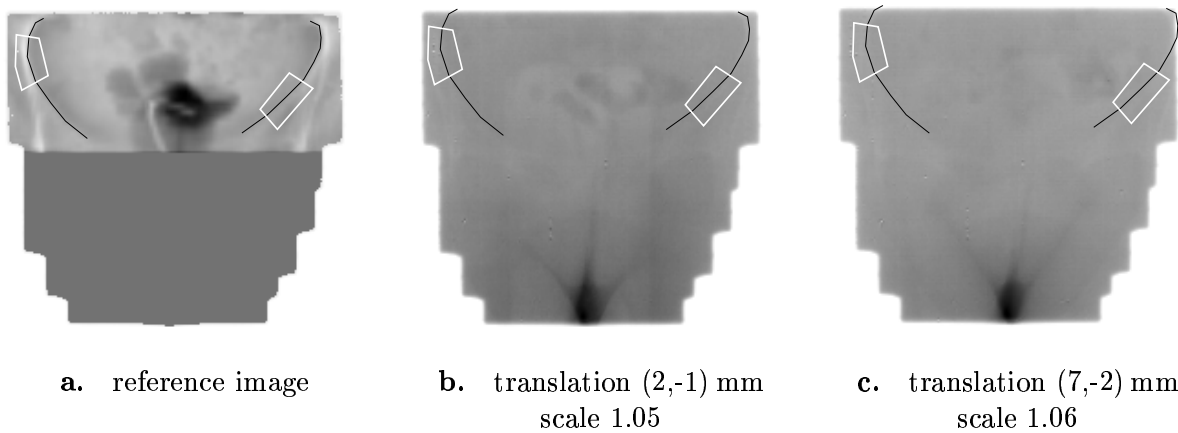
Multi-modal match between a DRR image computed from incomplete CT data (a) and a portal image series (b,c). The transformation model includes translation and scale. The white polygons outline the template regions and patches respectively, the black lines represent validation lines which are not used for matching.
